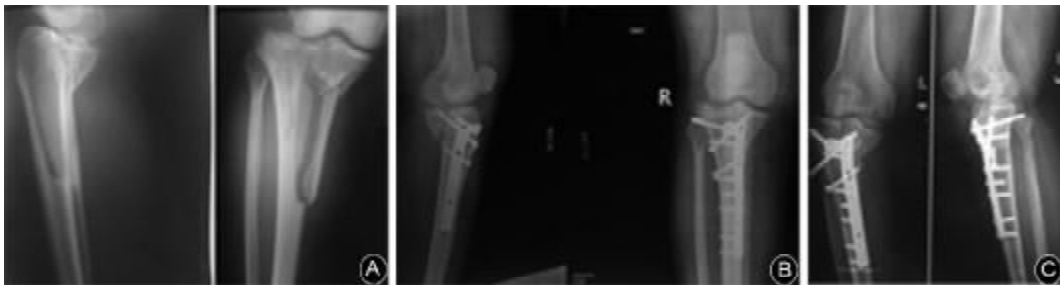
X-ray image of type IIIb2 fracture. A. before operation; B. after operation; C. genu varum appeared 8 months after operation.
